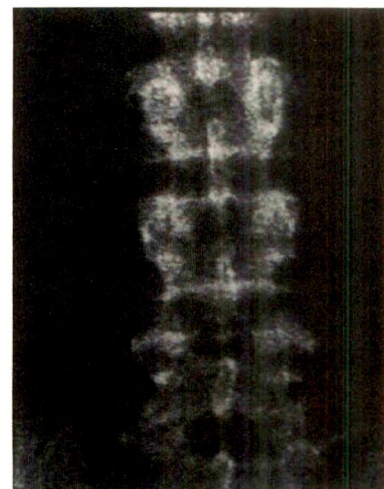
Representative scan images of lumbar spine from dual-energy radiographic absorptiometry with Hologic system.
